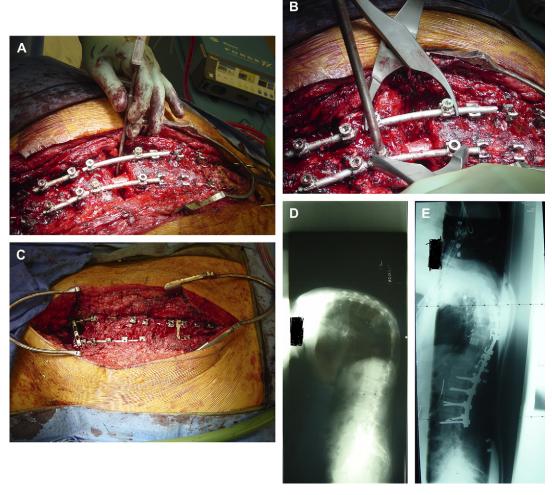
(A) VCR in a patient with severe circumferentially fixed thoracic kyphosis. Note the visual roll off of the kyphosis. (B) Compressors close the osteotomy on a custom-cut anterior pivot to allow the desired sagittal correction. (C) Osteotomy is fully closed. Note the sagittal correction visually demonstrated when compared with the image in A. (D) Preoperative radiograph of the fixed kyphosis. (E) Postoperative sagittal correction with a single VCR at the apex of the previous kyphosis.
